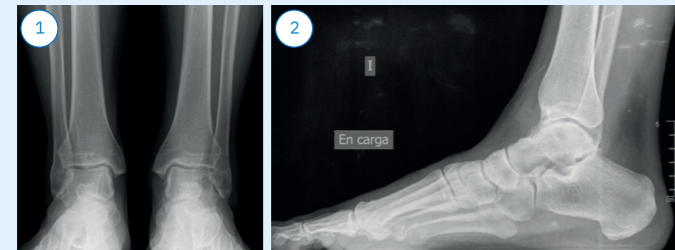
preoperative weight-bearing radiographs
